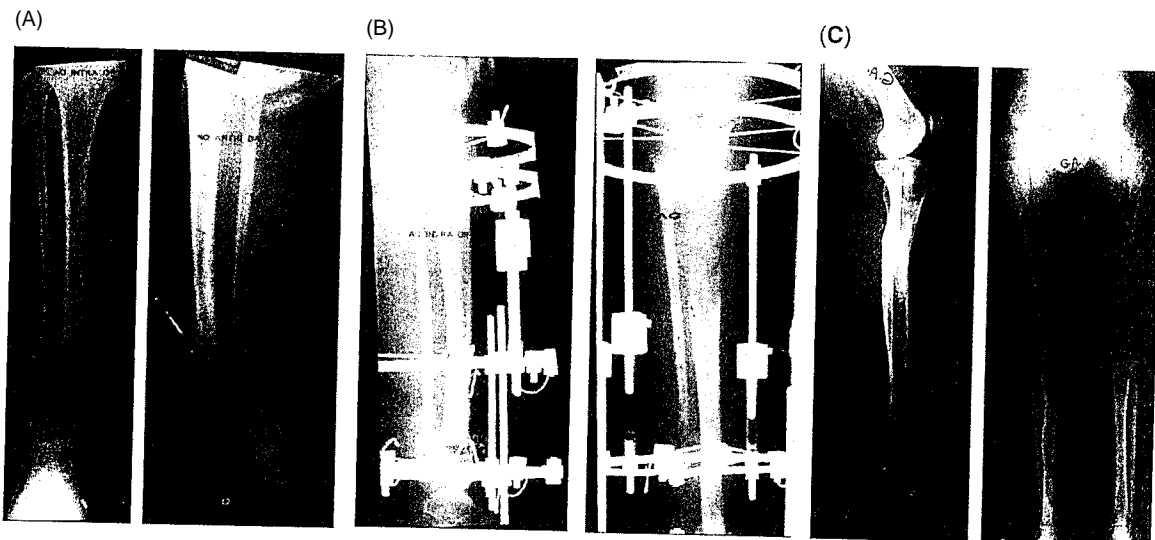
(A-C) Type II pseudarthrosis treatment. (A) Anteroposterior (AP) and lateral view radiographs of Type II pseudarthrosis in a 14-year-old girl after resection of bone ends. (B) Acute shortening and proximal osteotomy for lengthening of 10 cm. (C) AP and lateral views 11.5 years postoperatively show consolidation of CPT, good alignment, and equal leg lengths.
